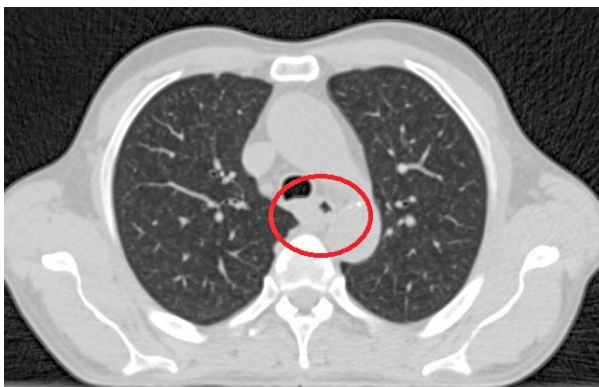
Spiral chest CT before treatment.
